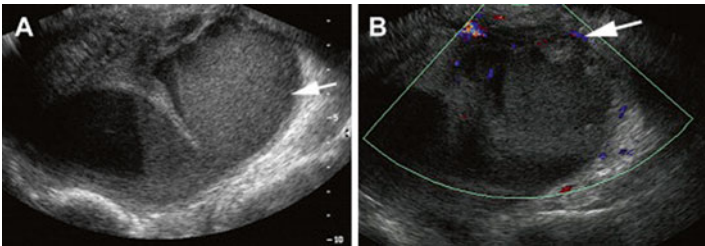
Pyosalpinx. (a) Transvaginal ultrasound shows serpiginous tubular structure (*arrow*) in the adnexa with low-level internal echoes, consistent with pyosalpinx. (b) Color Doppler sagittal ultrasound image shows peripheral vascularity along the inflamed fallopian tube (*arrow*) (Reprinted from Chu et al. [66], with permission from Elsevier)
